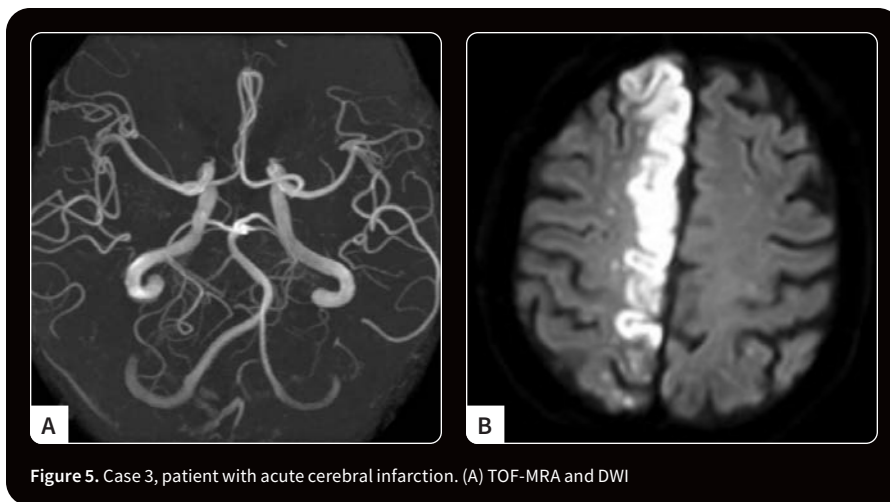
Case 3, patient with acute cerebral infarction. (A) TOF-MRA and DWI
